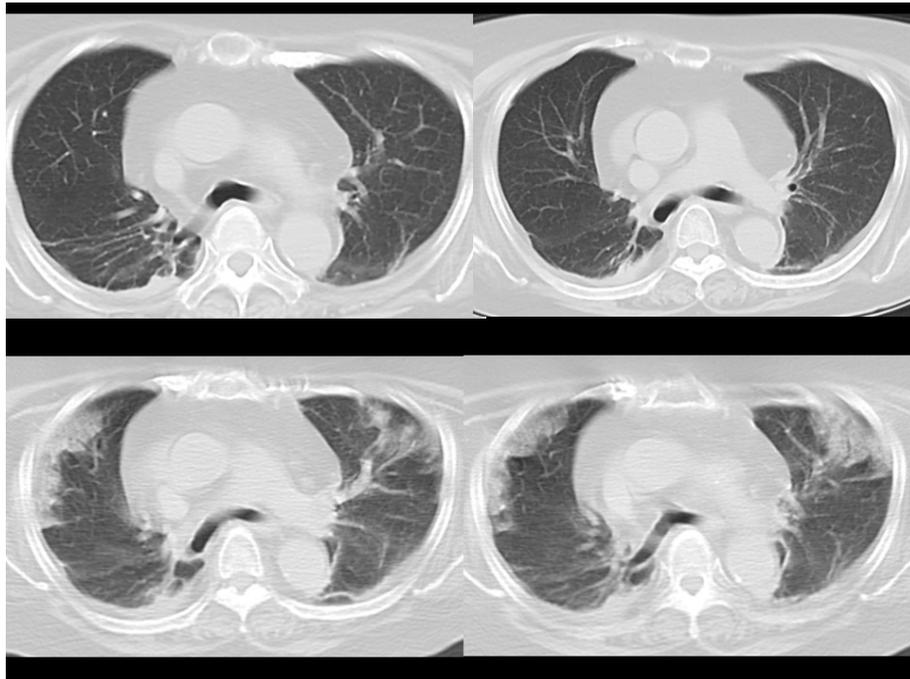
Chest computed tomography (CT) on arrival (upper) and the following day (lower). The CT showed clear lung fields with thin dorsal atelectasis in the supine position on arrival, but the following day, CT showed bilateral peripheral patchy ground-glass appearances
